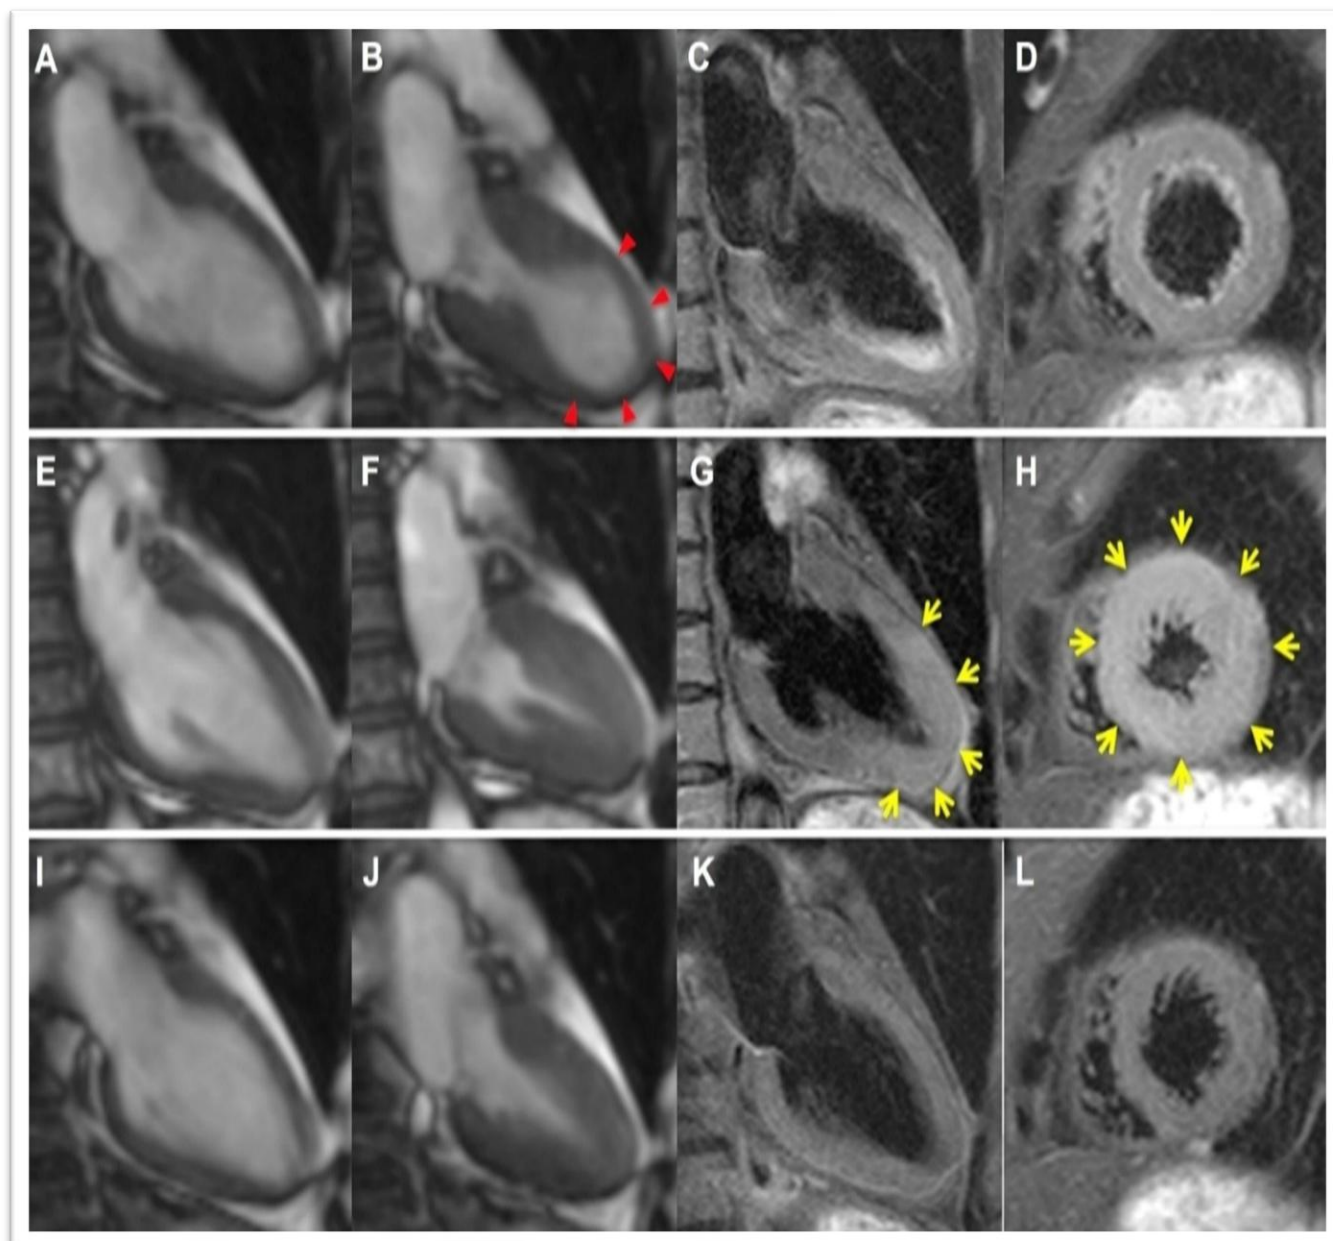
Cardiac Magnetic Resonance Imaging (CMR) Serial change of myocardial edema in a representative patient with TTS. In the acute phase, apical ballooning was observed ((A, B), red arrows). Myocardial edema on T2-weighted images was slight (C, D). In the subacute phase, wall motion was completely recovered (E, F), whereas more thickened apical wall with more severe myocardial edema was observed compared with the acute phase ((G, H), yellow arrows). In the chronic phase, the final CMR imaging demonstrated normal systolic function (I, J) without apical wall thickening or myocardial edema (K, L). CMR, cardiovascular magnetic resonance; TTS, takotsubo syndrome.
